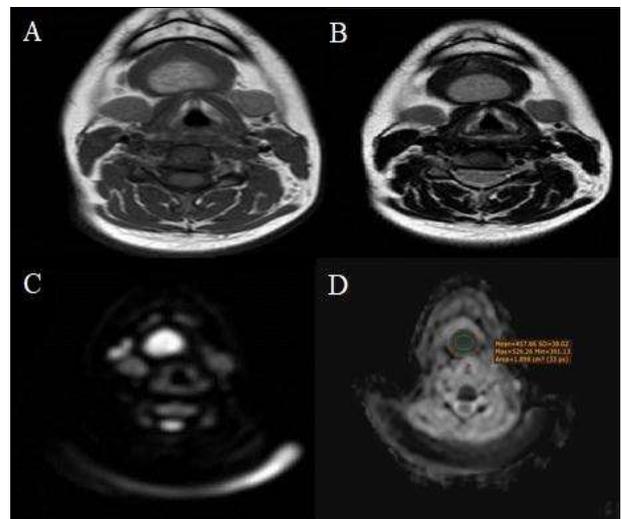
MRI findings: (A) a well-defined mouth floor cystic lesion that elicit high signal intensity at T₁WI, (B) intermediate signal intensity at T₂WI, (C) seen with restricted diffusion on DWI, (D) with low signal at ADC map with ADC value estimated to be $0.457 \times 10^{-3} \text{ mm}^2/\text{s}$
